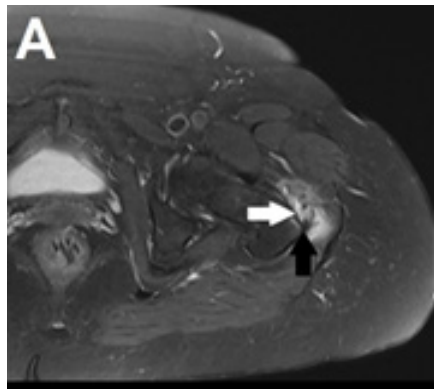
Axial T2 fat-suppressed (A), coronal T2 fat-suppressed (B), and coronal T1-weighted (C) magnetic resonance images showing a complete tear of the left gluteus minimus tendon (white arrow), associated gluteus medius tendinopathy (black arrow), and gluteus minimus muscle atrophy (blue arrow).
